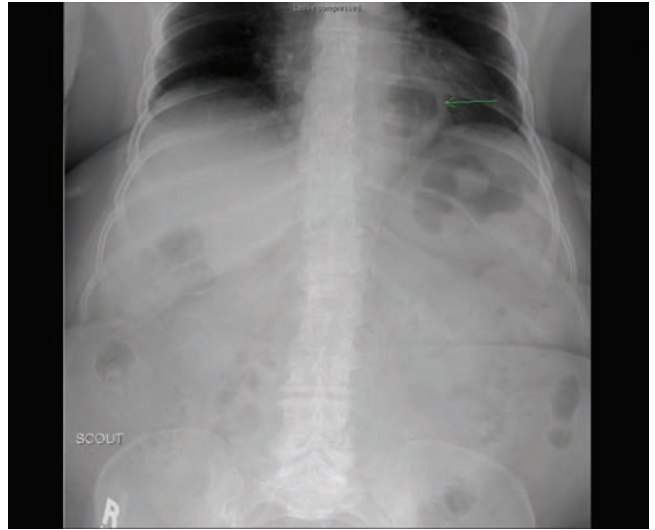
Chest x-ray—retrocardiac air-fluid level (arrow) resulting from intrathoracic stomach with paraesophageal hernia. (Used with permission from Saurabh Khandelwal, MD, University of Washington.)
